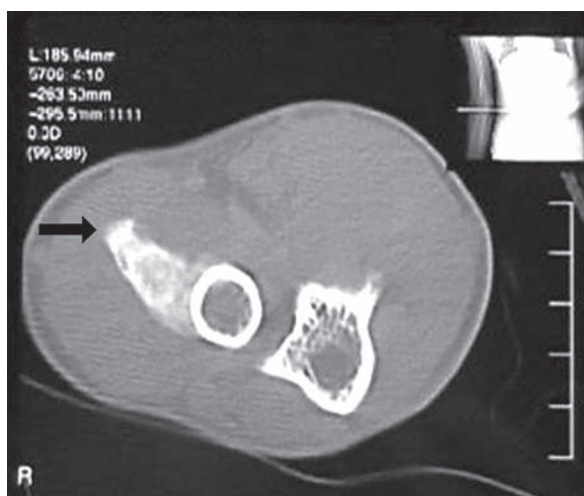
Proximal radial osteochondroma in computed tomography
